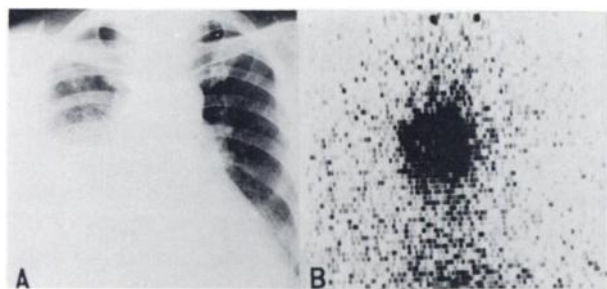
(A) Chest x-ray shows hydrothorax in right lower lung field. (B) Scintigram clearly demonstrates localized tumor within shadow of hydrothorax.
